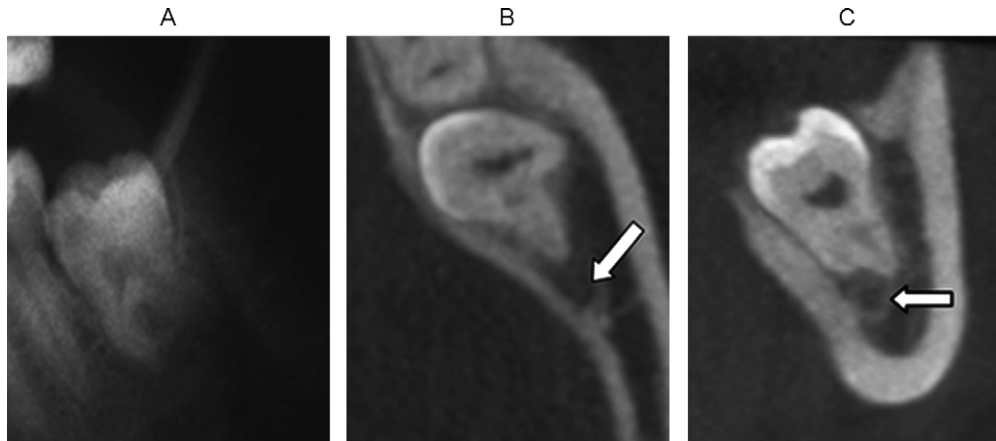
Panoramic radiograph showing darkening of the distal root and interruption of the superior white line of the mandibular canal (A). Transverse (B) and coronal (C) CBCT images show the presence of bone tissue between the mandibular canal and third molar root (arrows). The neurovascular bundle was not exposed during removal as was expected from the CBCT images.
